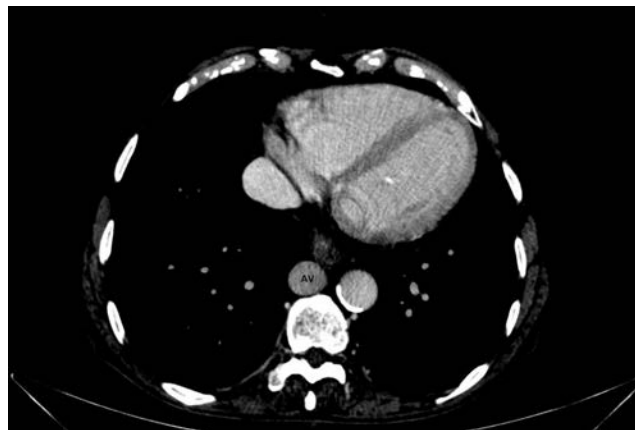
The abdominal computed tomography (CT) scan showing the azygos vein (AV).
